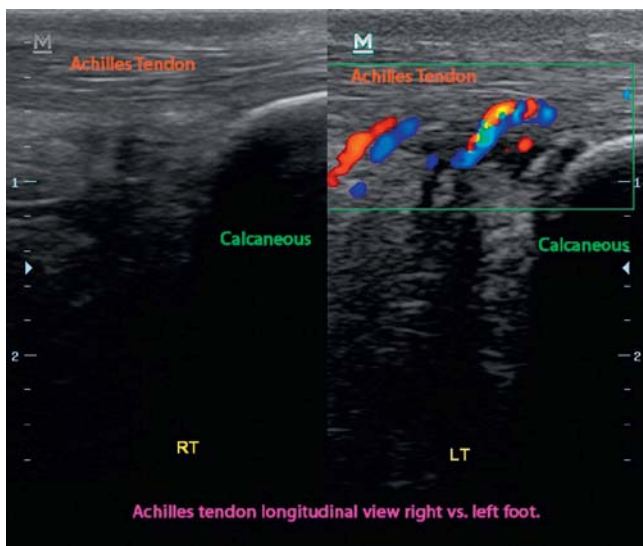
Longitudinal color Doppler image of tendinitis of the left Achilles tendon. Note the neovascularity when compared with the right.
